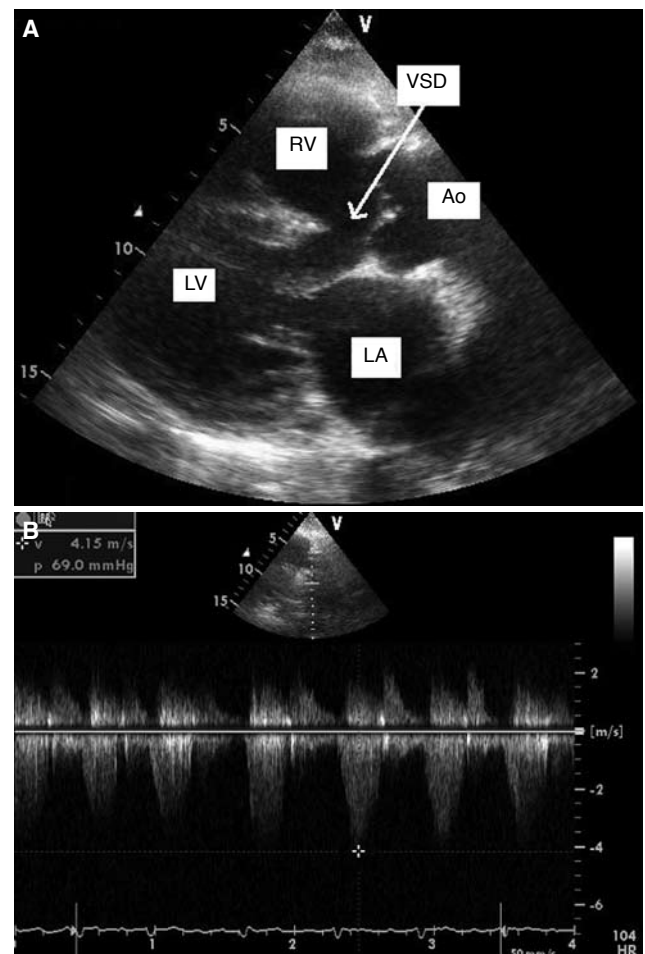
(A) Parasternal long axis view of tetralogy of Fallot. VSD: Ventricular septal defect; RV: Right ventricle; Ao: Aorta; LV: Left ventricle; LA: Left atrium. (B) Continuous wave Doppler image of the pulmonary valve from the parasternal short axis view showing a pressure gradient of 69 mmHg.
